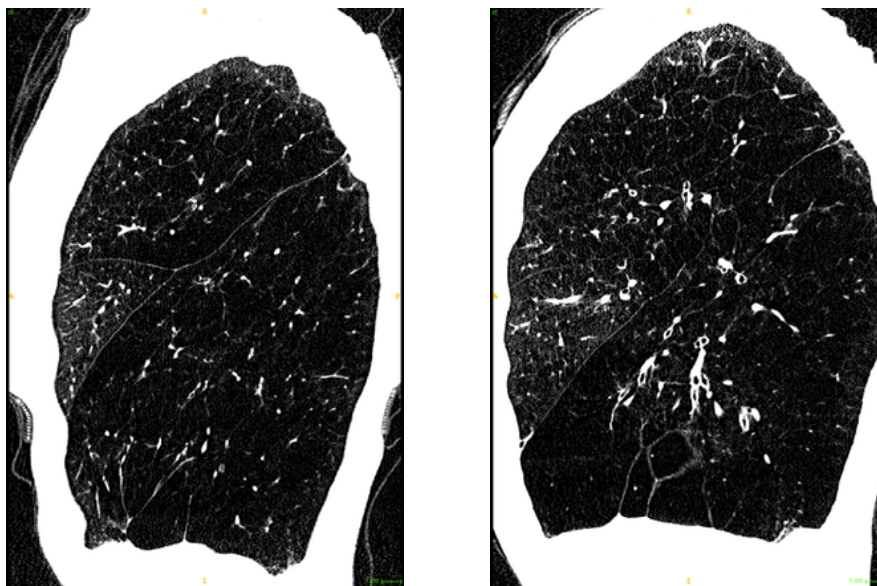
On the left: A sagittal slice of a right lung CT-Scan; Fissures are complete and clearly visible. On the right: A sagittal slice of a right lung CT-Scan; Fissures are incomplete.
